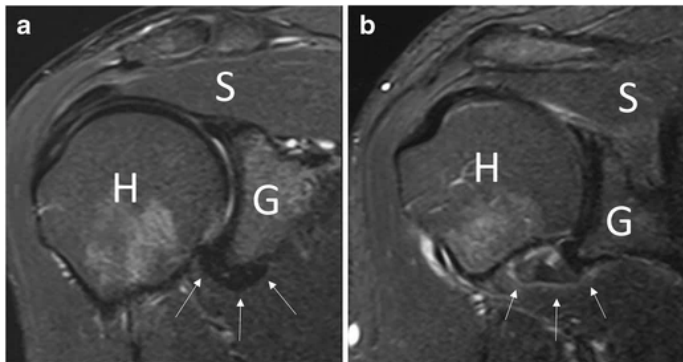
Coronal MRI image weighed in T2 saturated with fat. Image *b* shows thickening (up to 10mm) and hyperintensity of the signal of the glen-humeral ligament complex of the axillary sac with hyperintensity/edema of adjacent soft tissues [97].
